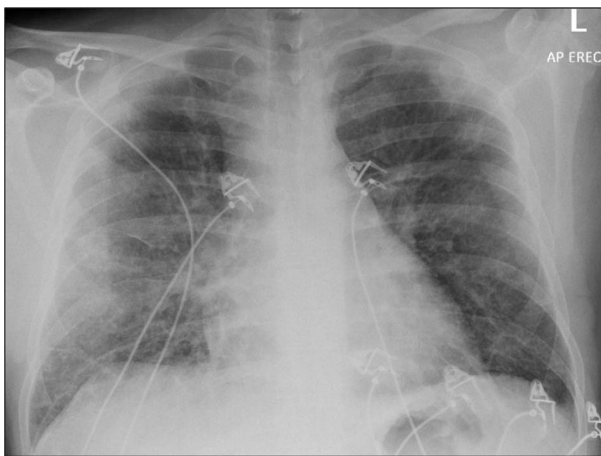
Chest radiograph from day of medical hospital admission showing bilateral widespread air-space opacification—more pronounced on the right, with blunting of the left costophrenic recess.
